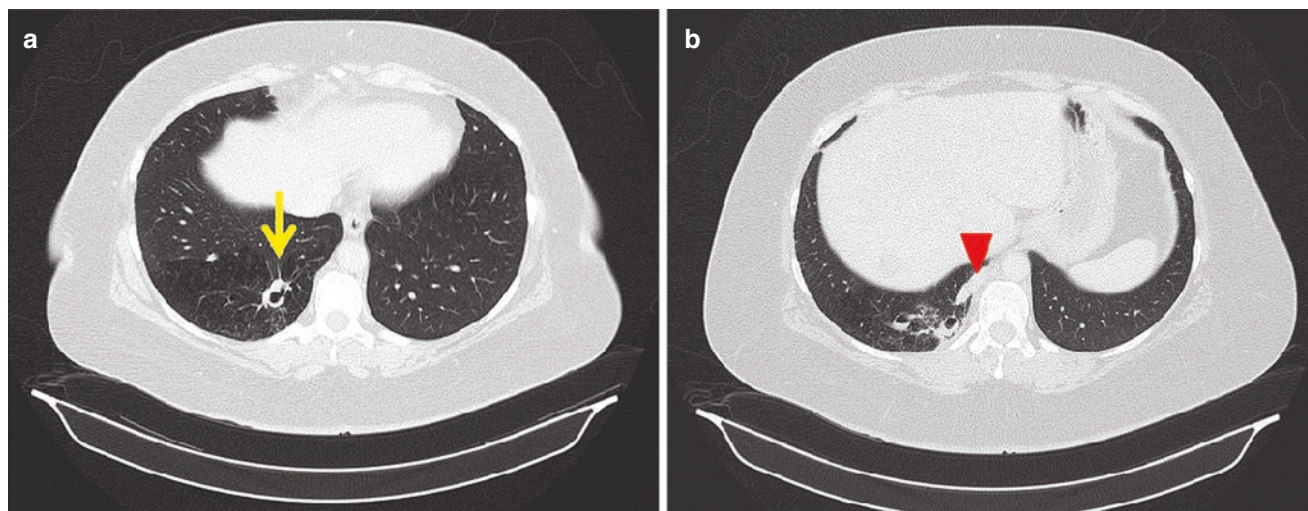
(a, b) CT imaging findings in intralobar sequestration (yellow arrow). The entirety of the lesion consists of a homogeneous area of hypodensity with smooth contours, containing a large feeding vessel
